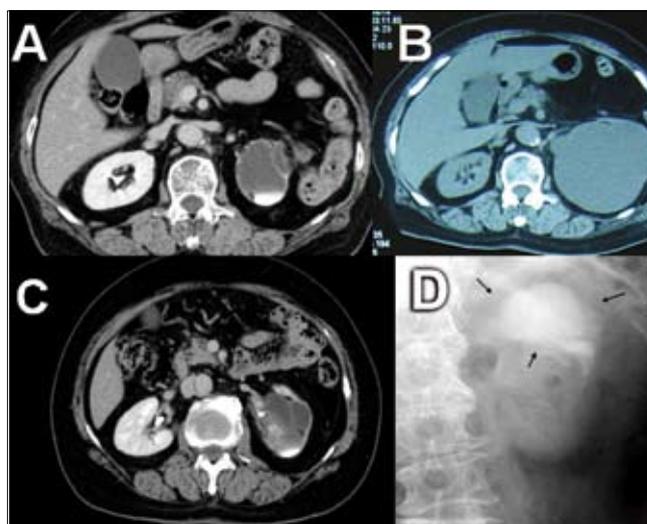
Contrast enhanced CT demonstrates that contrast medium enters diverticula, with free level within the cyst (Fig. 1A). CT revealed a cystic lesion 20 x 11 cm that was larger than the previous one (Fig. 1B). The contrast enhanced CT and scout film demonstrates that PCD reduced in size 6 months after operation (Fig. 1C and D).
